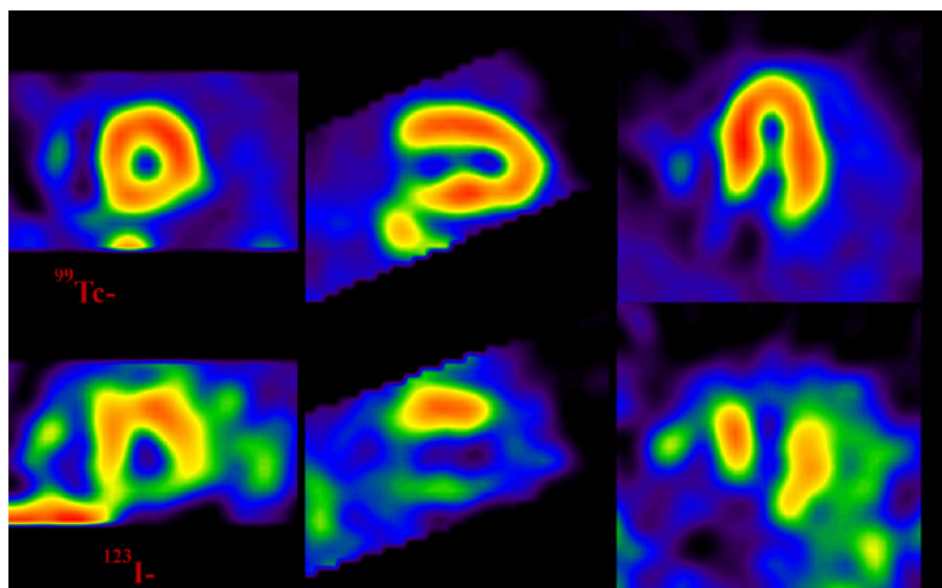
Patient with acute coronary syndrome (ACS). Normal myocardial perfusion scintigraphy (MPS) with Sestamibi-^{99m}Tc (top row). Myocardial scintigraphy (MS) with MIBG-¹²³I (bottom row) demonstrates uptake defects in apical segments, suggestive of Takotsubo syndrome. Reduced tracer uptake is additionally observed in the inferior wall. Personal source.
